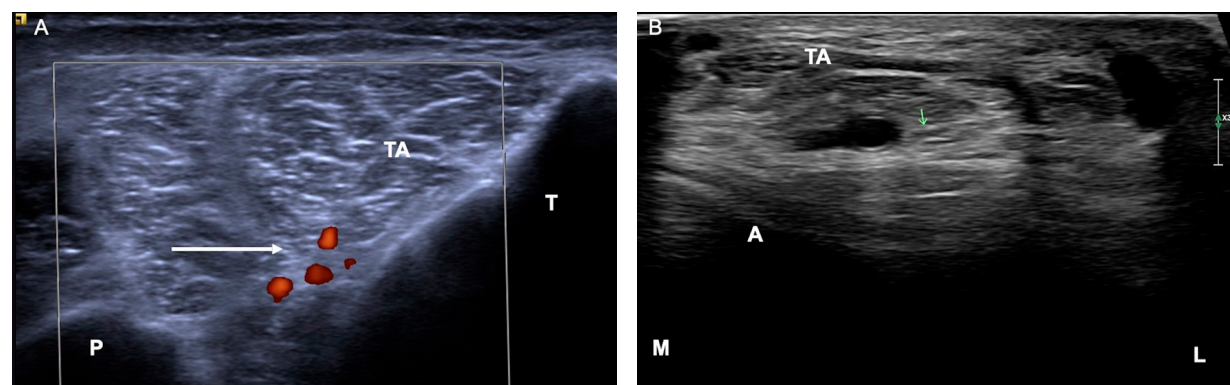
a) Axial Doppler image in the leg, the deep peroneal nerve (arrow) is located ventral to the interosseous membrane below the anterior tibial muscle (MTA) (T: tibia and P: perone). b) Image in the transverse plane, the deep peroneal nerve (arrow) is observed lateral to the anterior tibial artery (TTA: anterior tibial tendon, A: talus, M: medial, L: lateral).
